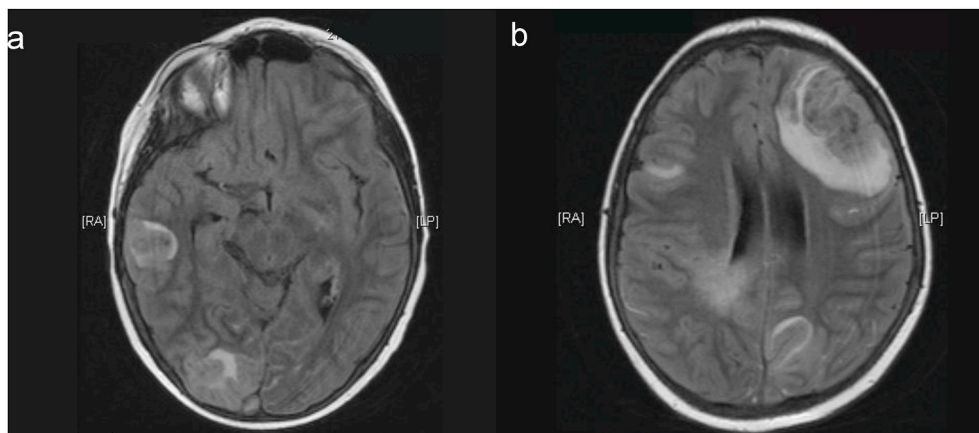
Cerebral infiltration of the mucormycosis. Head MRI (a + b, transversal FLAIR – fluid-attenuated inversion recovery) reflecting the cerebral lesions due to septic embolic infarctions and bleeding.
